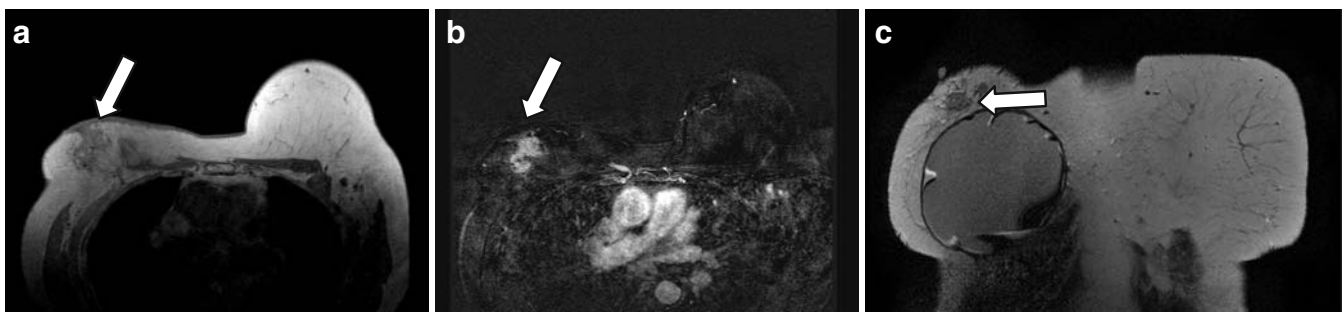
Case number 8131 of November 17th, 2008; 70 year-old patient, right radical mastectomy in 1999 and breast reconstruction with expander changed for implant in 2003; dynamic study before the Gadolinium injection (A), subtraction (B) in the transverse plan and T2-weighted sequence in the coronal plan (C) showing an enhancement mass in the breast reconstruction suggesting recurrence disease (white arrows).
